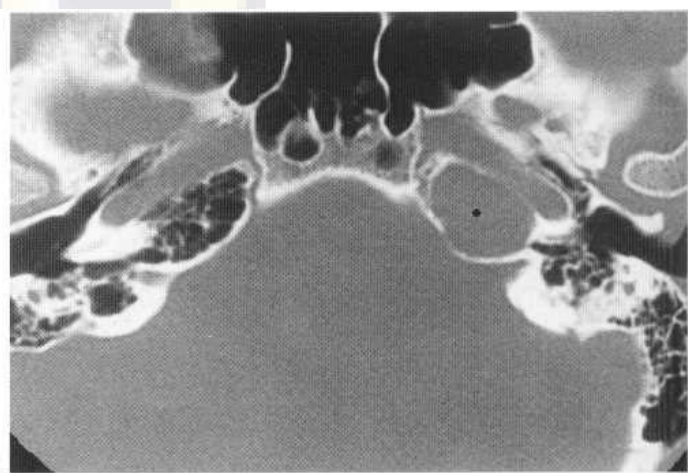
(A) Axial CT section showing an expansile lesion in the petrous apex (asterisk). This was a presumed cholesterol granuloma following trauma. Note the good pneumatisation of the petrous apex on the other side. (B) High signal on both T_1 - and T_2 -weighted MR protocols confirmed that this was a cholesterol granuloma.
